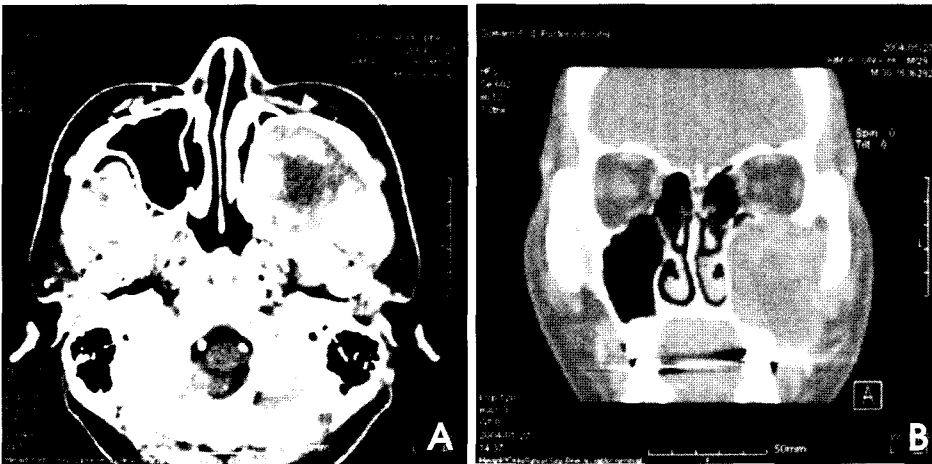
A: Axial enhanced CT shows bowing-in of the left maxillary sinus posterior wall and displacement of the pterygoid plate. B: Coronal CT shows displacement of the nasal wall and thinning of the orbital floor.
